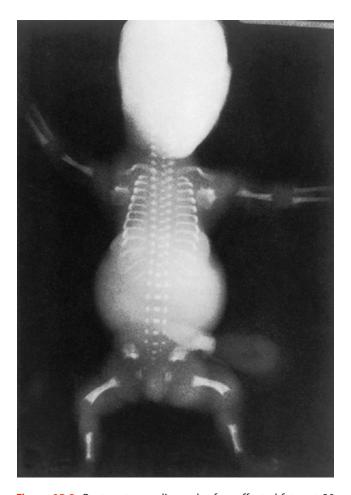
Postmortem radiograph of an affected fetus at 20 weeks of gestation demonstrating the marginal spurs on the femur characteristic of SRPS type III. The narrow ribs are especially well visualized. (*Reprinted, with permission, from Wu M-H, Kuo P-L, Lin S-J. Prenatal diagnosis of recurrence of short rib polydactyly syndrome.* Am J Med Genet. 1995;55:279-284. Copyright 1995 John Wiley & Sons. Reprinted, by permission, of John Wiley & Sons, Inc.)
